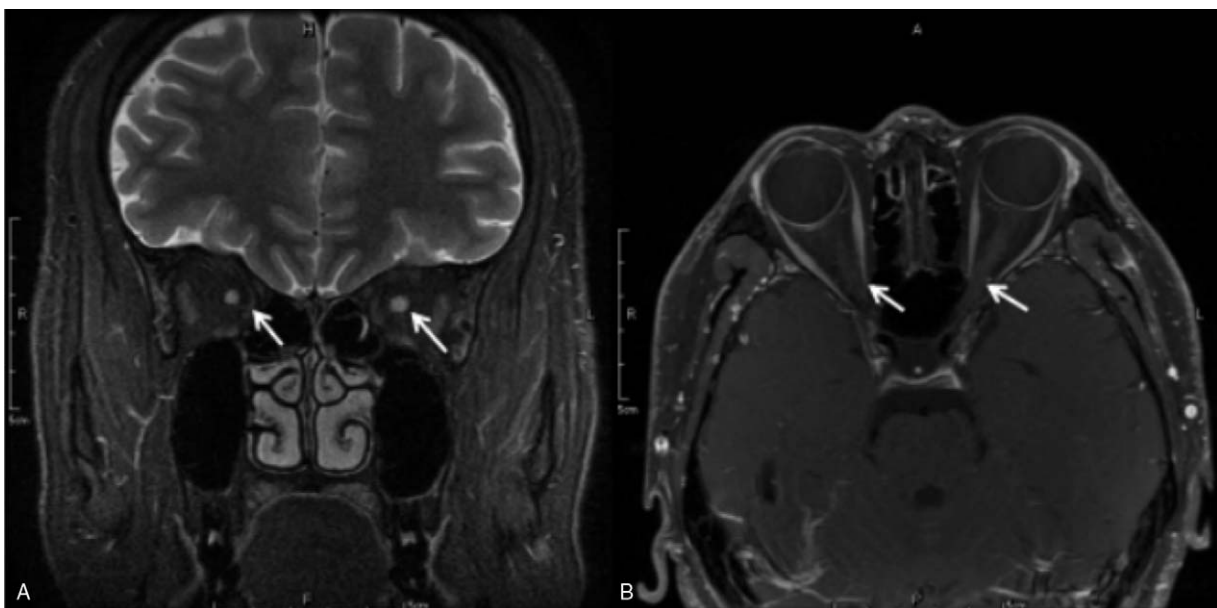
A: coronal scan, B: horizontal scan. Orbital MRI revealed long T2 signals in the intraorbital segment, intracanalicular segment and intracranial segment of left eye and intraorbital segment of right eye, meanwhile showed slight enhancement.
